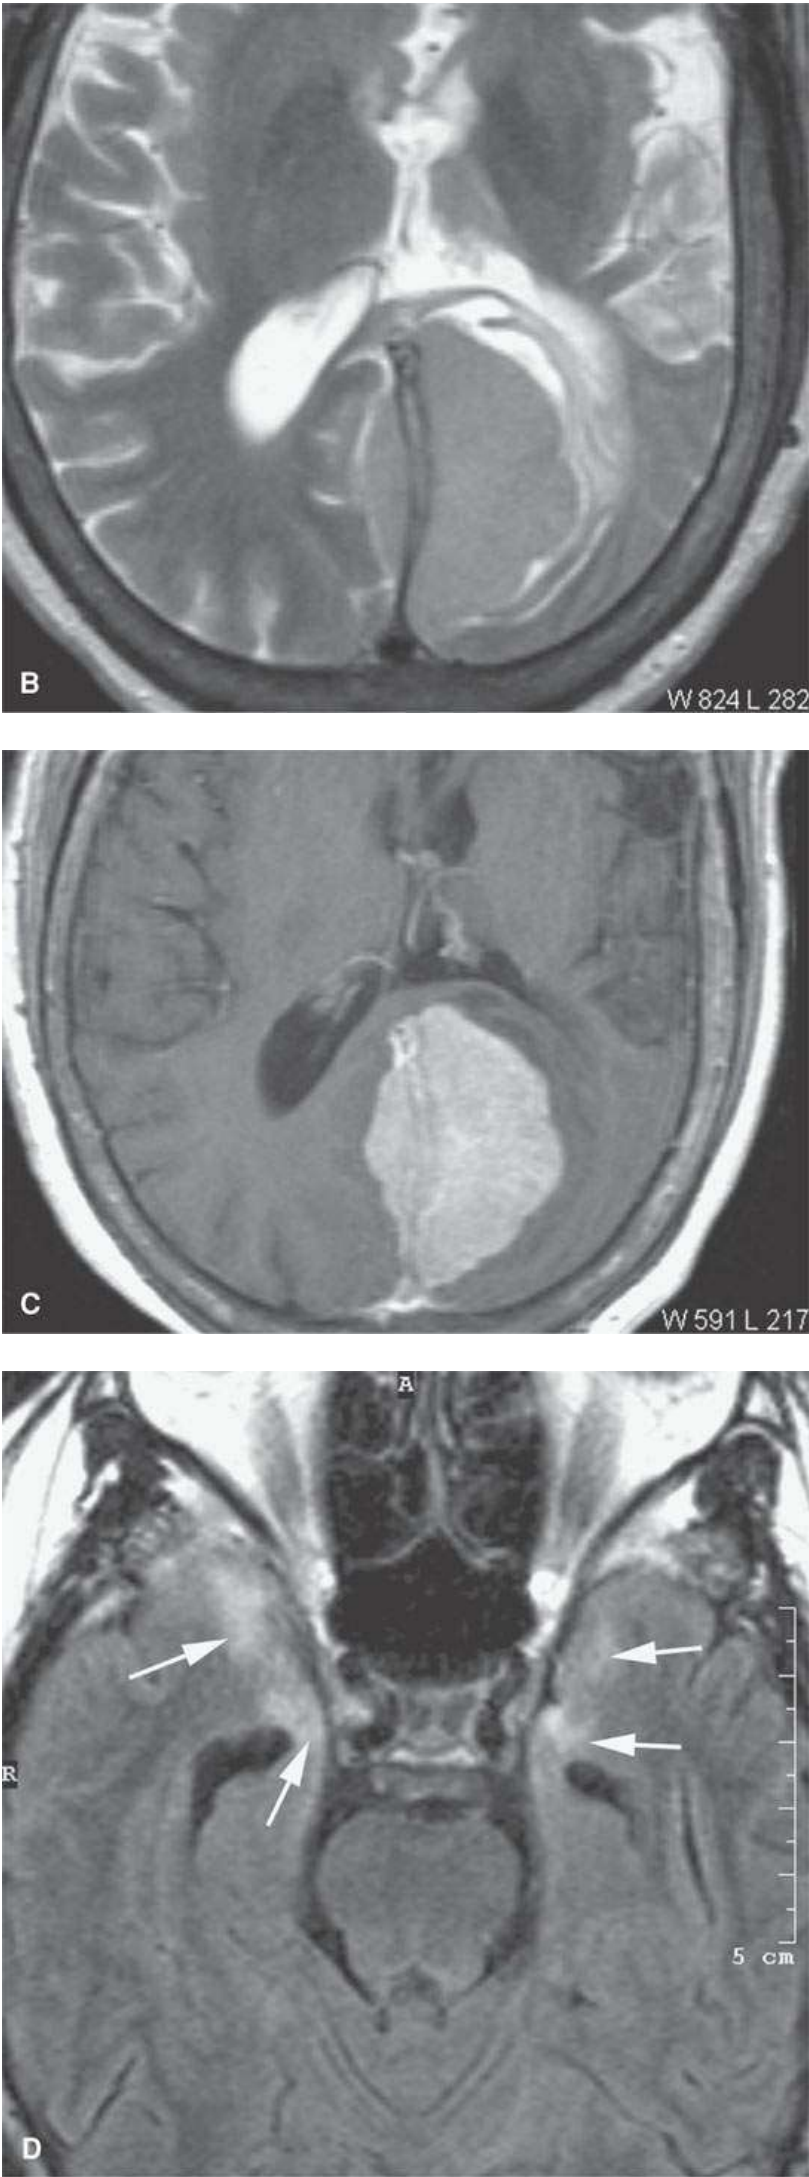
Magnetic resonance imaging of a patient with central nervous system disseminated non-Hodgkin lymphoma. A: Non-contrast-enhanced T1-weighted (T1W) image showing dural mass. B: T2-weighted (T2W) image showing the lymphoma to be isointense to gray matter. C: Contrast-enhanced T1W image to correlate with (B) showing dural mass to enhance quite a bit. D: T2W fluid attenuation inversion recovery (FLAIR) image showing the cortical and subcortical effects (*arrows*) of predominantly dural disease.
